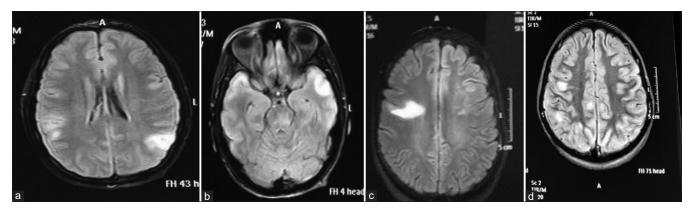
(a-d): MRI brain T2 FLAIR axial sequences showing large fluffy cortical, and subcortical hyperintensities in patients with MOG antibody positive disease
